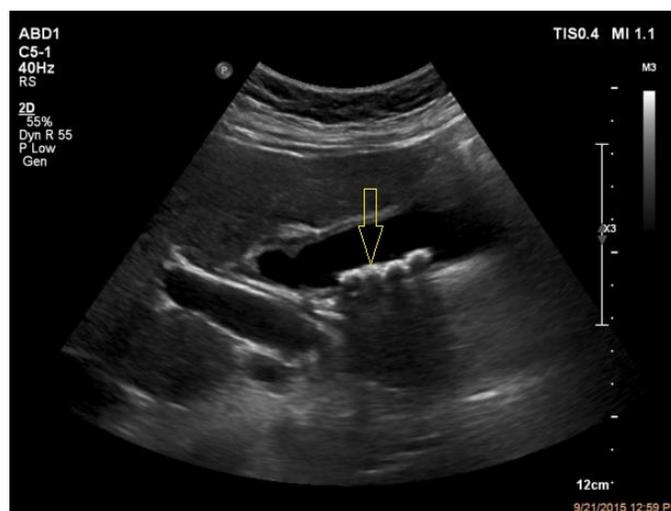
Abdominal ultrasound – gallbladder with multiple hyperechoic images with posterior shadow cone.
